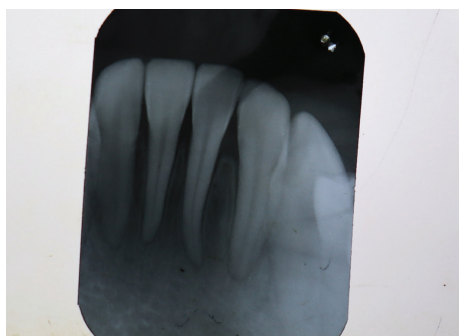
Intra- oral periapical radiograph showing interdental bone loss in relation to 31.
